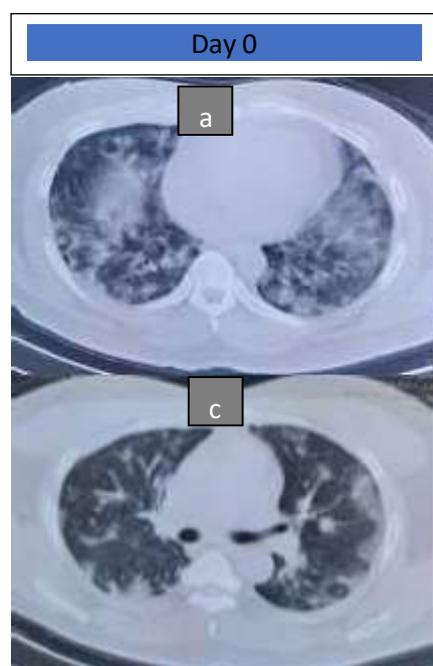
Chest X-ray of Covid-19 patient at the time of admission showed the patient had bronchopneumonia, consolidation was seen in the peribronchial paracardial paracardium with GroundGlass Opacity (GGO) and an increase in coarse brocovascular markings.
